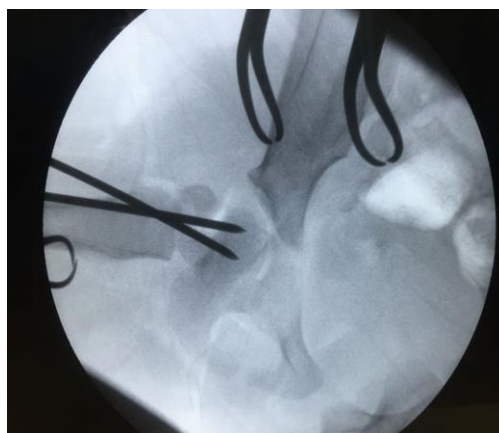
C-ARMLateral radiograph during the operation
